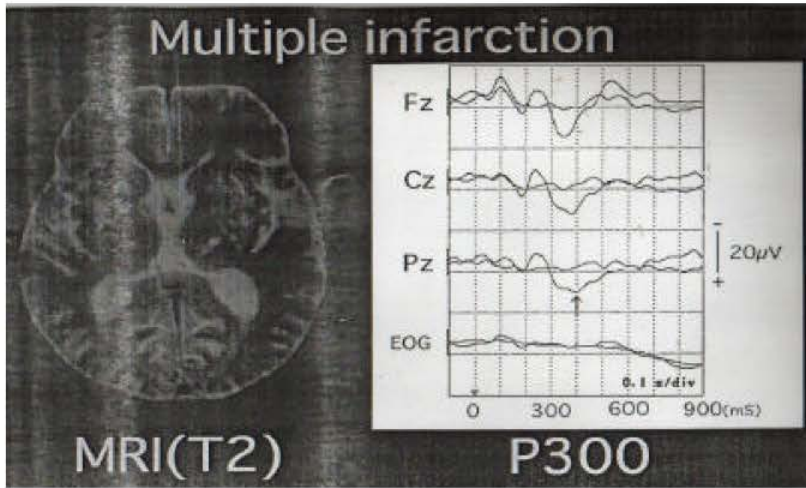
The MRI of multiple lacunar infarction in T2-weight image with prolonged P300 average waveforms of ERPs obtained from Fz, Cz, Pz and EOG in responses using a standard auditory oddball stimulus paradigm
